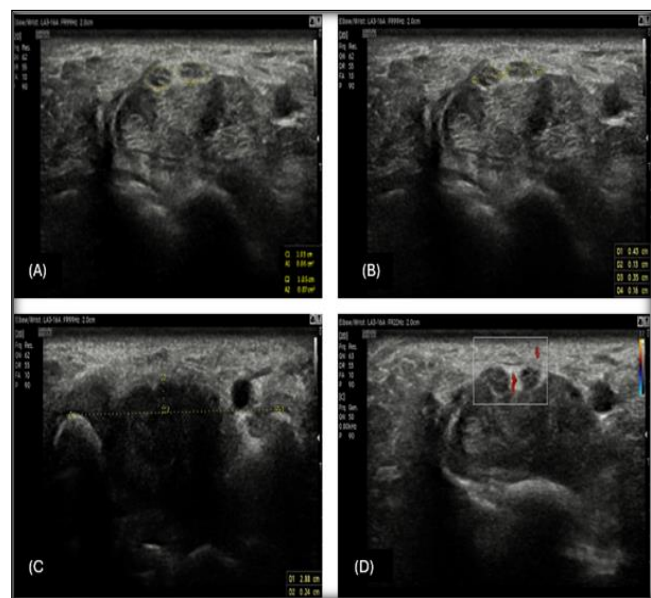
Ultrasound and Doppler findings in Grade III CTS with bifid median nerve and persistent median artery
